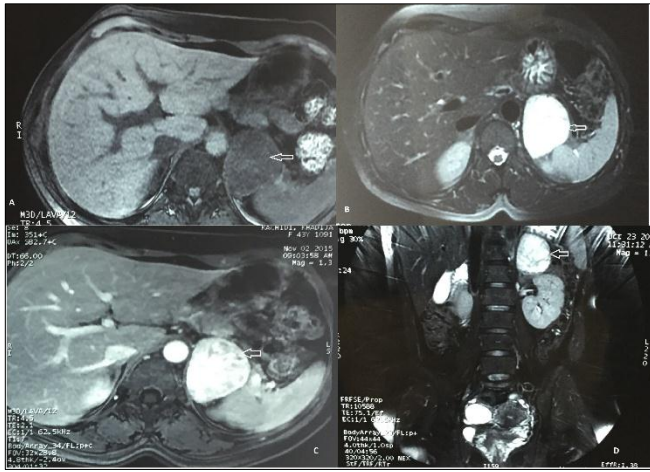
MRI of abdomen showing the slightly hyposignal of the left adrenal mass on T1 weighted MR image (A), markedly hyperintense on T2 (B). Cystic and solid enhancing components are depicted in a post-contrast MR image on T1 weighted with fat saturation; axial (C) and coronal (D)
